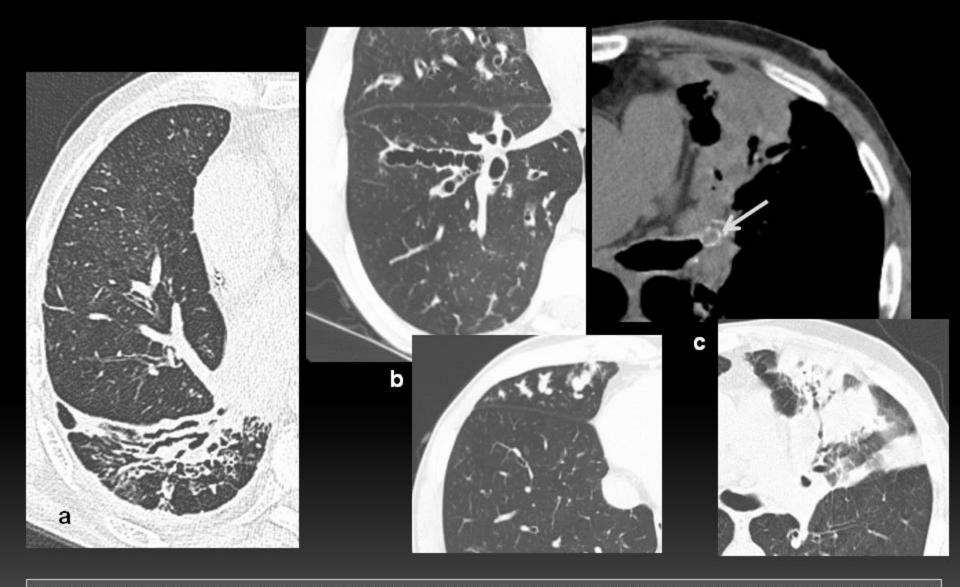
a – Man, 60 years old with bronchitis and hemoptysis. CT shows cylindrical bronchiectasis in superior segment of right lower lobe. b- Man, 65 years old with recent pneumonia and hemoptysis. CT reveals varicose bronchiectasis in right lower lobe and broncoceles in middle lobe. c – Man, 65 years old and blood streaked sputum. CT discloses a foreign body partially calcified (arrow) in lingular bronchus, cylindrical bronchiectasis and lung collapse/consolidation.
